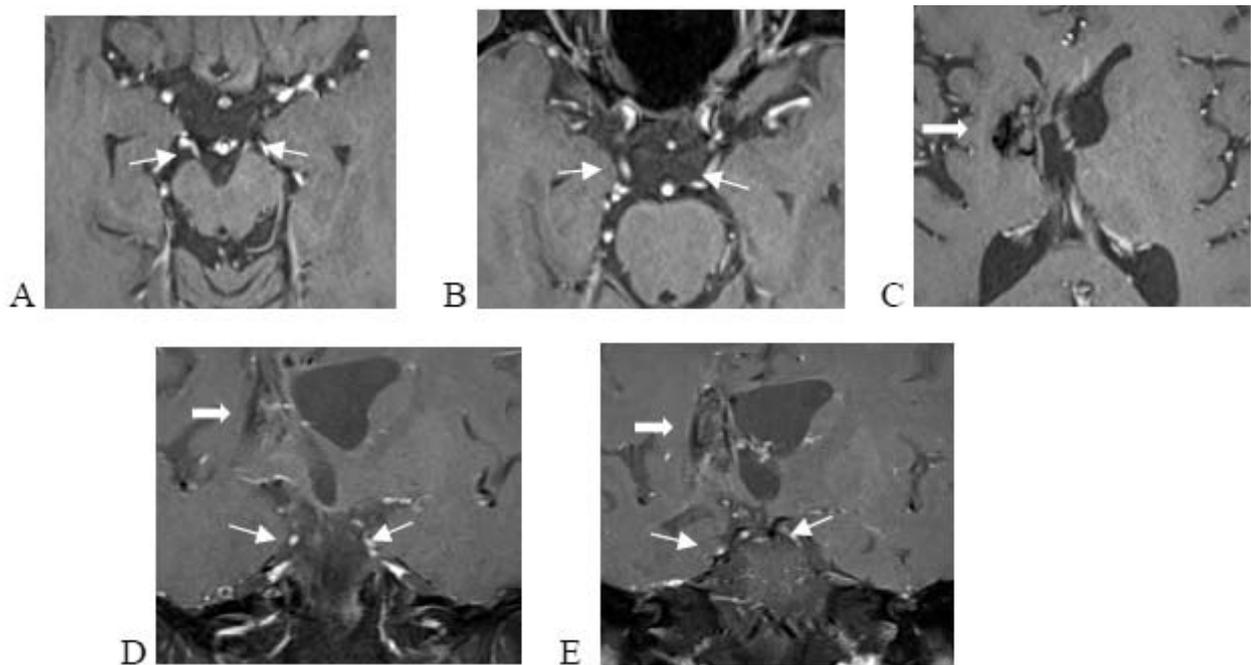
Case 8: Radiation-induced cranial nerve injury: A 33-year-old male, known case of right basal ganglia germinoma underwent surgery and radiation 10 years ago. MRI of the brain axial (A, B, and C) and coronal (D and E) post gadolinium T1WI shows smooth enhancement of cisternal portion of bilateral CN III (A, B, D and E, white arrows). Area of prior tumor involvement in right basal ganglia remained as parenchymal volume loss and hemosiderin deposition (C, D and E, white thick arrow).
